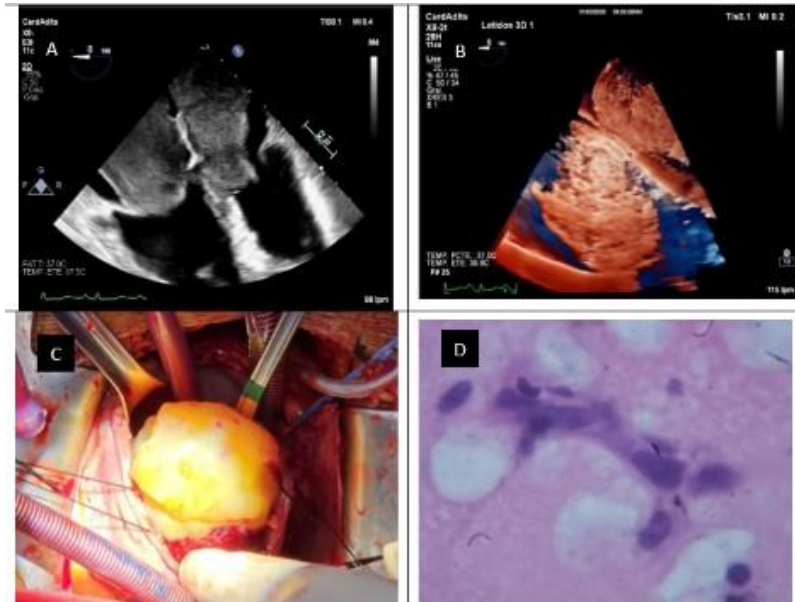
A.) Apical four-chamber view at 0° showing large, round echogenic masses that go through the valvular plane. B) 3D-TEE four chamber view at 0° showing the two masses attached to the interatrial septum. C.) The right atrial mass is exposed through a right atriotomy D.) Pathology shows a neoplastic process characterized by low cell density formed by spindle-shaped or stellate cells with a small ovoid, elongated or stellate nucleus, abundant clear slightly vacuolated or eosinophilic cytoplasm with a poorly defined cell membrane surrounded by abundant eosinophilic myxoid intercellular matrix
